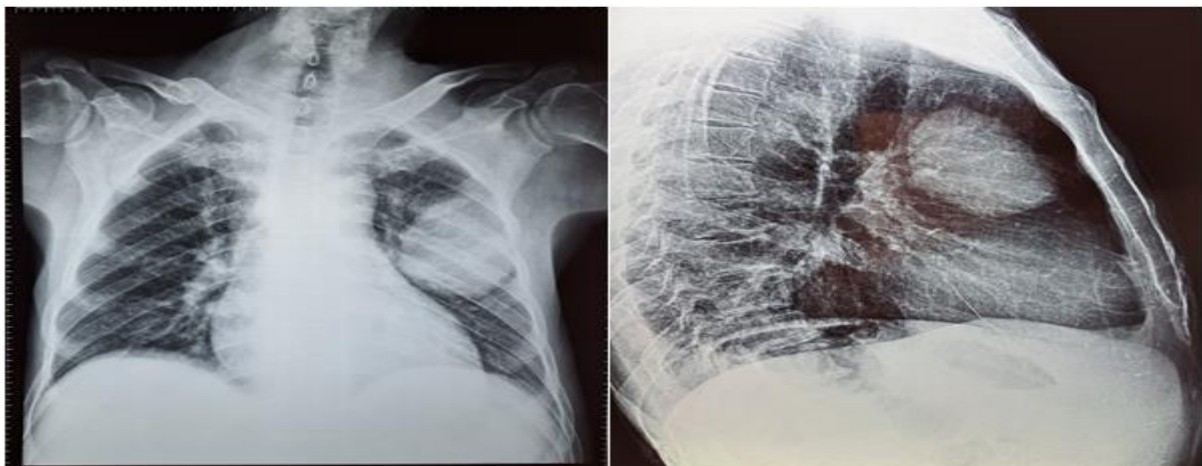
Frontal Chest X-Ray
